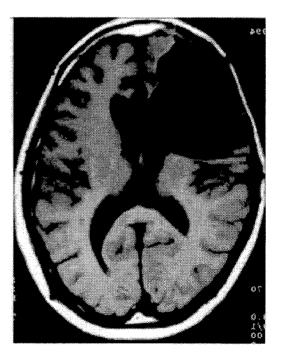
11F, Oligo-astrocytoma (G3). Planning (left) Oct. 1981 at MulTR. Follow up MRI (right) in 1994. Radiation dose at target pint was 23Gy.
